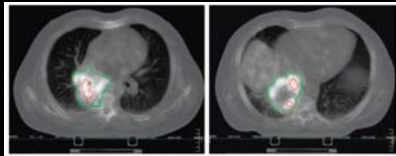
Two axial CT scan images of patient 1 with inadequate tumor coverage by GTV<sub>ref</sub> (red) in PET-CT fusion image.
